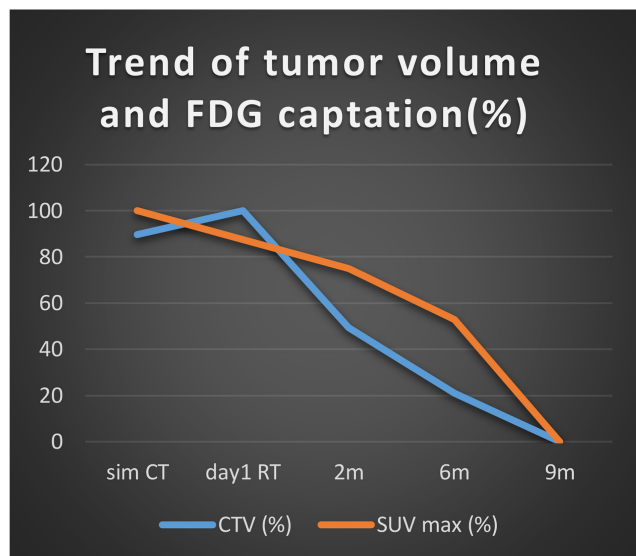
Trend of tumor volume and FDG captation. The graph shows the progressive percentage reduction in tumor volume (blue line) and metabolic activity (orange line) at radiological assessment during FUP.
